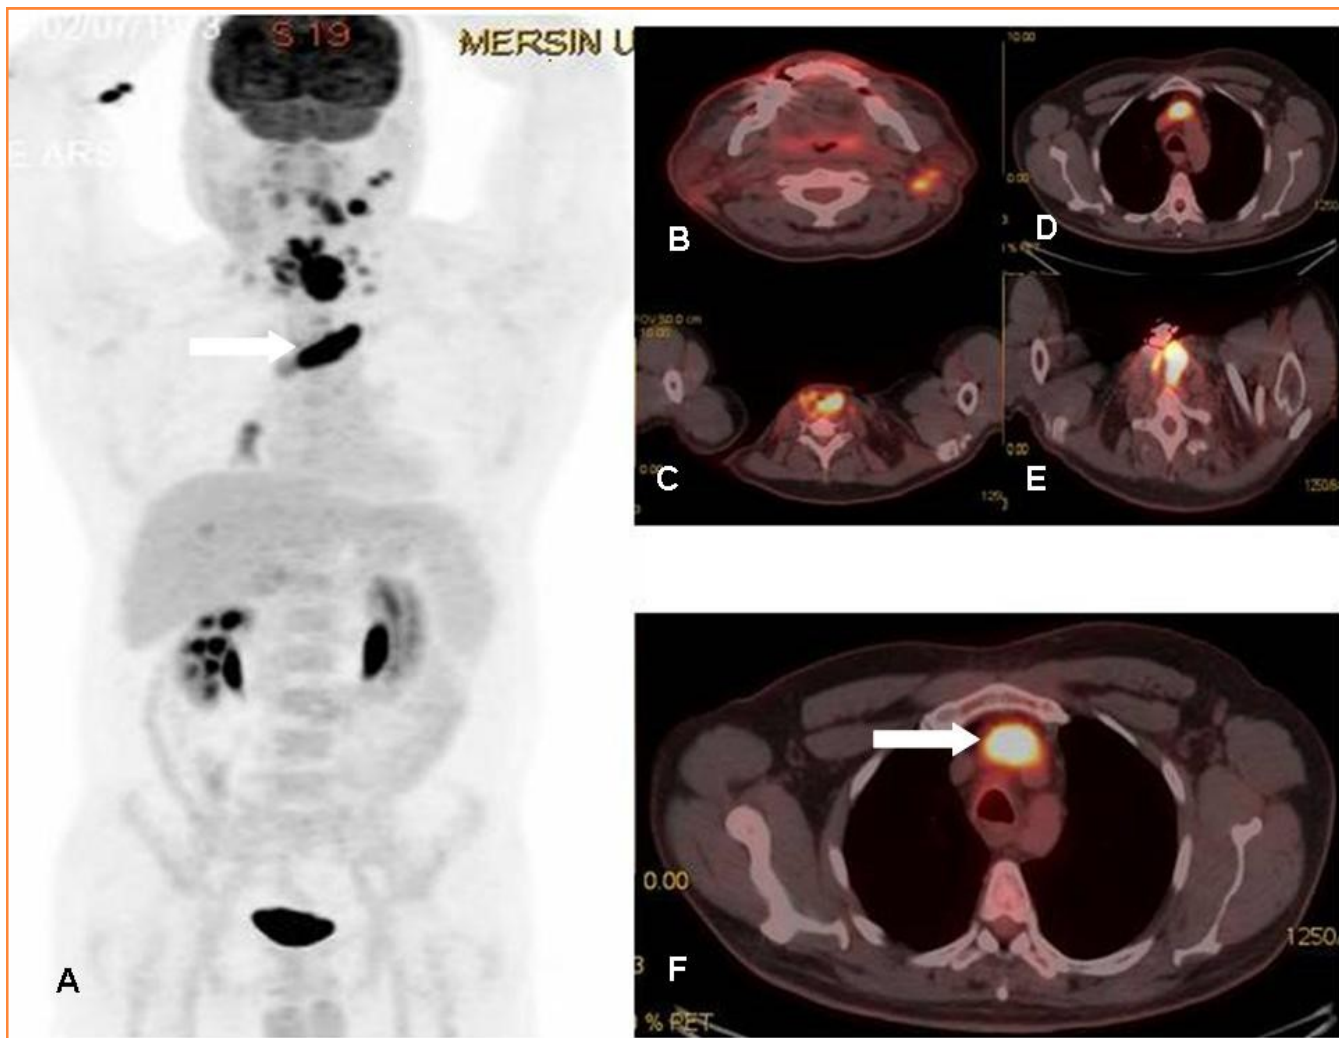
MIP (Maximum intensity Projection-A) and axial PET-CT fusion (B-F) images demonstrate recurrent mass lesion, metastatic lymphadenopathies and tumor thrombus (white arrows).
